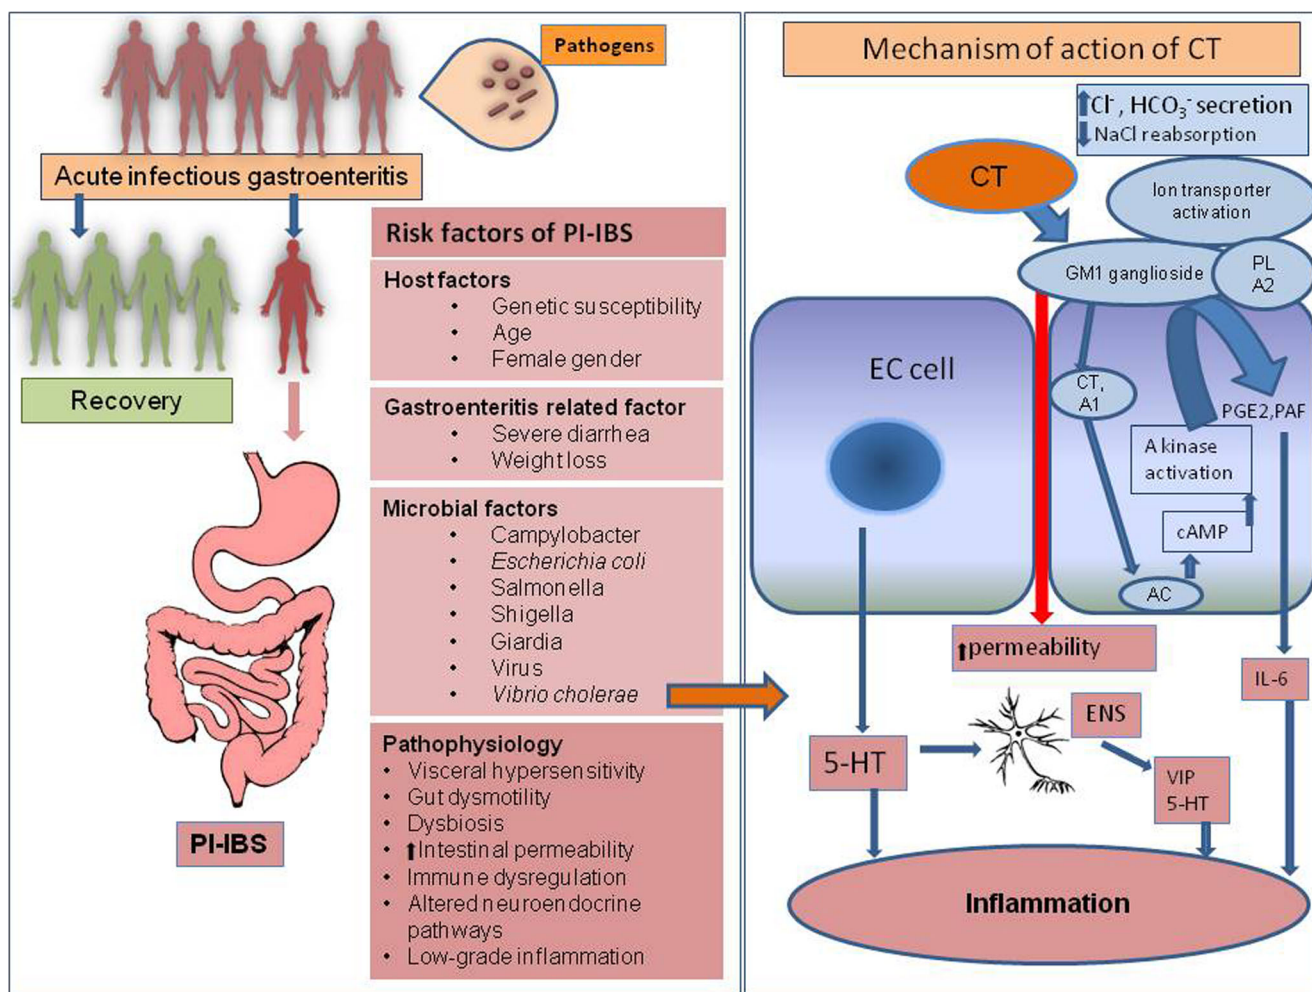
Risk factors and pathophysiology of post-infection irritable bowel syndrome (PI-IBS) and mechanism of action of cholera toxin. *CT* cholera toxin, *AC* adenylate cyclase, *PL-A2* phospholipase A2, *PGE2* prostaglandin E2, *PAF* platelet activating factor, *5-HT* 5-hydroxytryptamine, *ENS*
